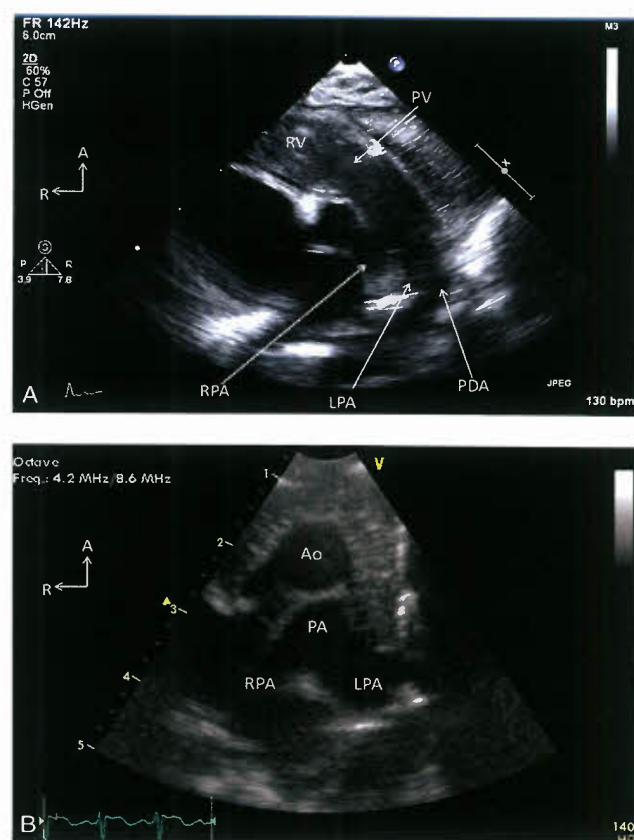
Parasternal short-axis images demonstrating different relationships between the great vessels. A: An echocardiogram from an infant demonstrates the identifying features of a pulmonary artery with its bifurcation into right and left pulmonary arteries (RPA, LPA). This view is called the “3 finger view” as it also demonstrates the PDA. The great vessels are normally related with the pulmonary valve (PV) lying anterior and left of the aorta. B: In a patient with D-transposition of the great vessels, both semilunar valves are in cross section in the parasternal short-axis view. The aorta (Ao) is identified as the anterior and slightly rightward vessel. The main pulmonary artery (PA) lies posterior to the Ao and bifurcates into RPA and LPA. A, anterior; R, right; RV, right ventricle.
